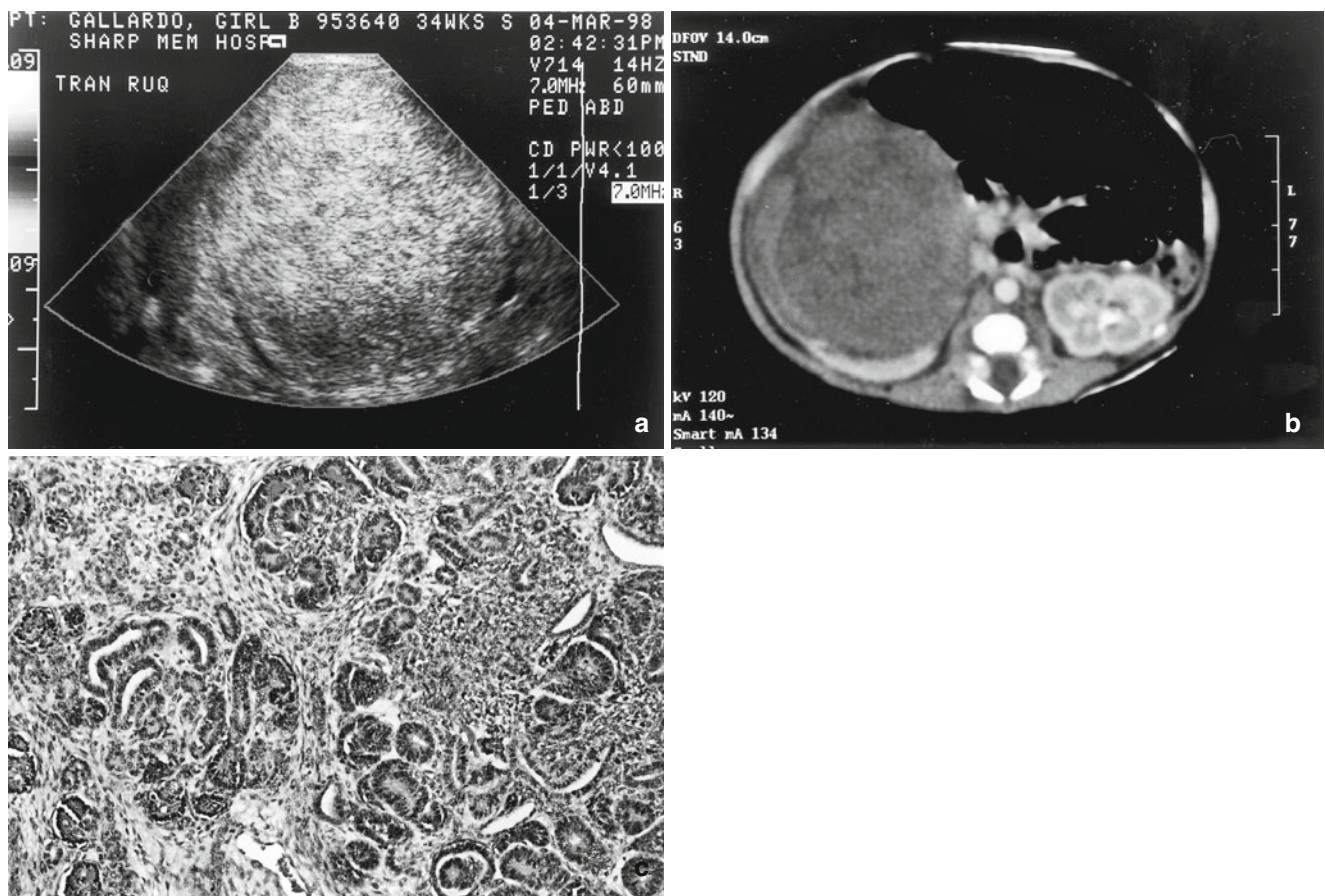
Congenital Wilms' tumor ($6 \times 5 \times 4$ cm, 98 g, stage 1). Six-day-old female, one of twins, with an abdominal mass detected on prenatal ultrasonography at 34 weeks gestation. (a) Prenatal ultrasound showing the abdominal mass. (b) Abdominal CT scan reveals the tumor replacing most of the right kidney. The classic peripheral "claw sign"
